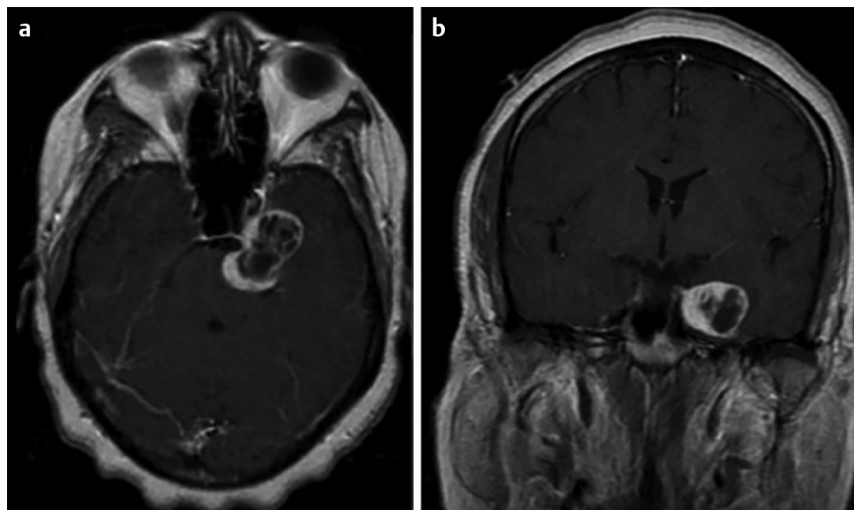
Preoperative MRI. (a) Axial and (b) coronal MRI with gadolinium showing a dumbbell-shaped enhancing mass in the region of the left Meckel's cave.
